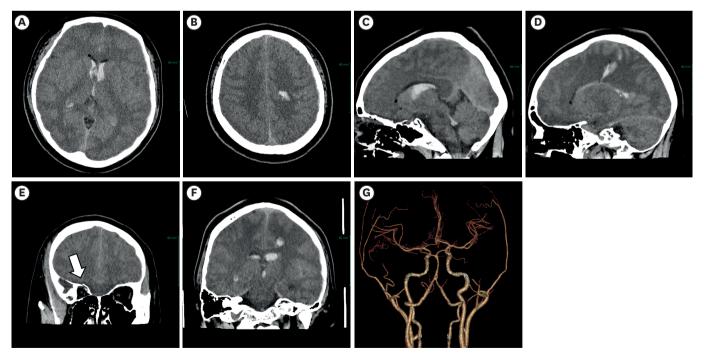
Initial brain CT of patients with transorbital penetrating brain injury. (A-F) An initial CT shows a longitudinal contusion extending from the right frontal lobe to the left parietal lobe with intraventricular hemorrhage. Fractures of the orbital roof were also observed (E, white arrow). (G) CT angiography revealed no major artery damage. CT: computed tomography.
